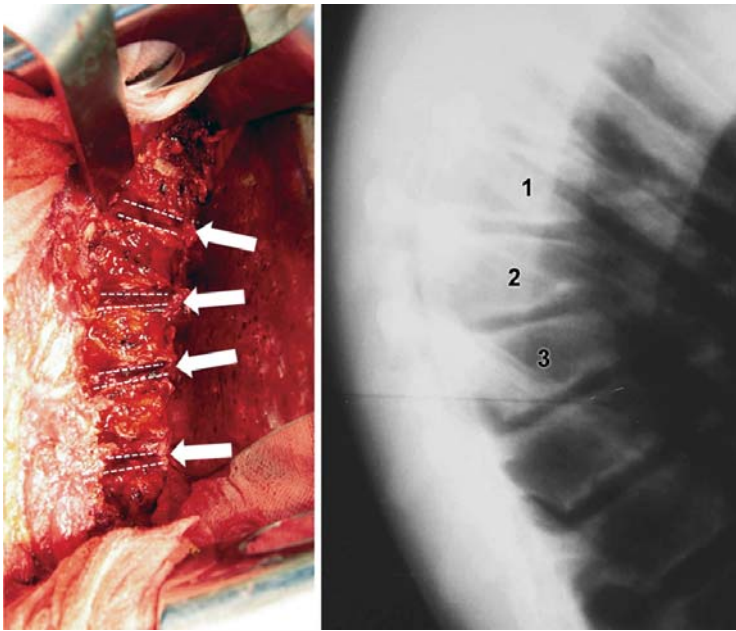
Left, an intra-operative picture from our series showing a complete discectomy at 4 contiguous levels after excision of the rib heads. The broken white lines mark the end plates and the bold arrow points to the disk space that is 'opened' by an anteriorly directed force with a fist over the apex of the kyphosis. Right, a preoperative hyper-extension radiograph shows the 'opening' of the disk spaces.
